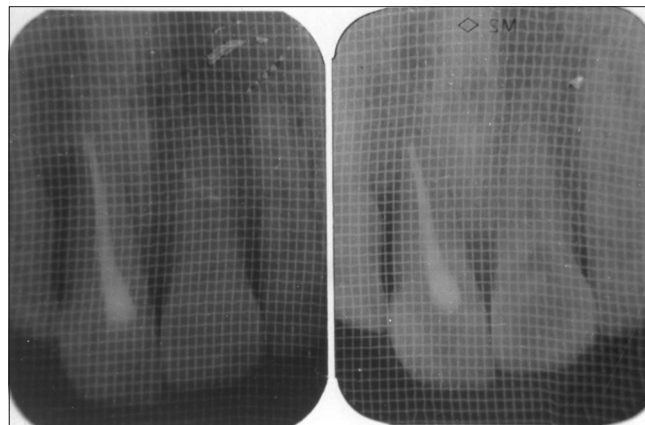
Pre and post x-rays showing bone level changes in the incisor area
